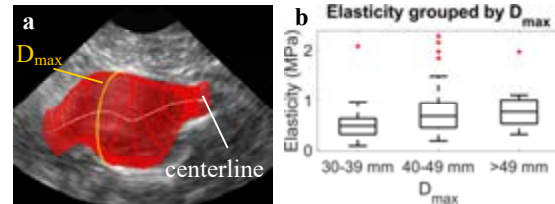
Geometry plotted on the ultrasound data. b: Box-and-whiskers plots of elasticity grouped by D_{max} .
